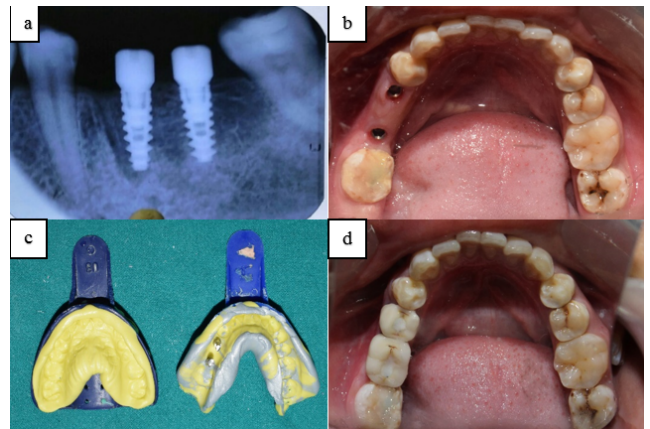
a: Post operative radiograph; b: Healed peri-implant mucosa; c: Close tray impression; d: Cementation of prosthesis.
